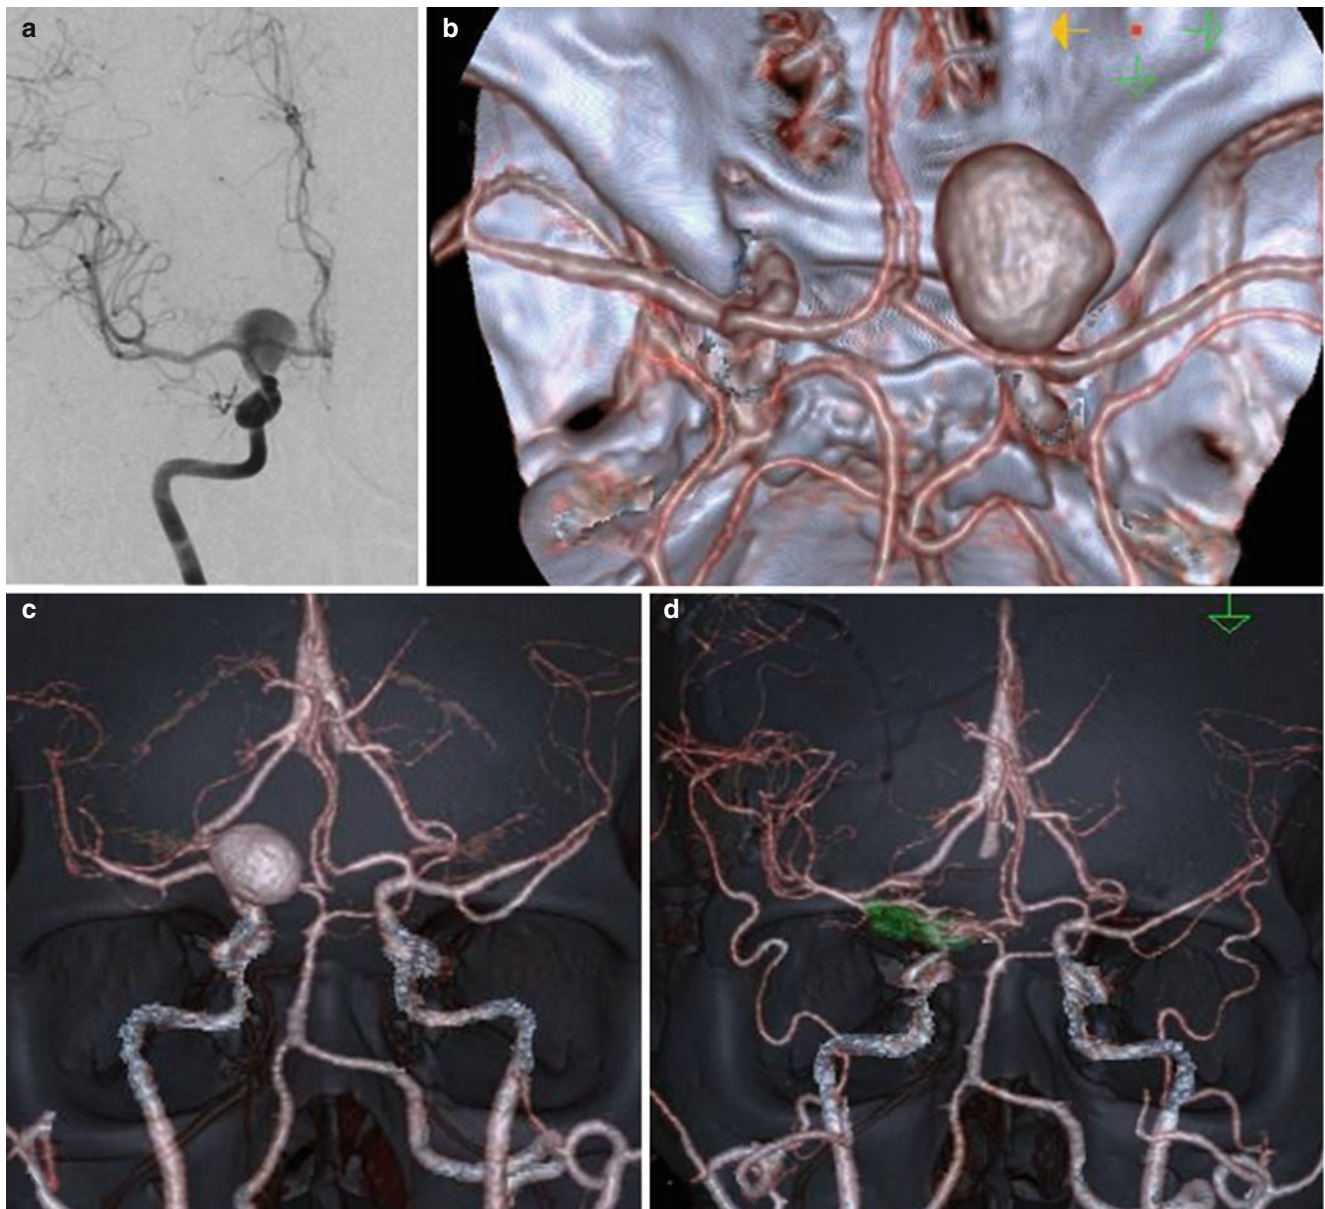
Preoperative right carotid angiogram (a) and 3-D CTA (b, c) showing the large dorsal aneurysm. Postoperative 3-D CTA (d) showing the complete clipping of the aneurysm
